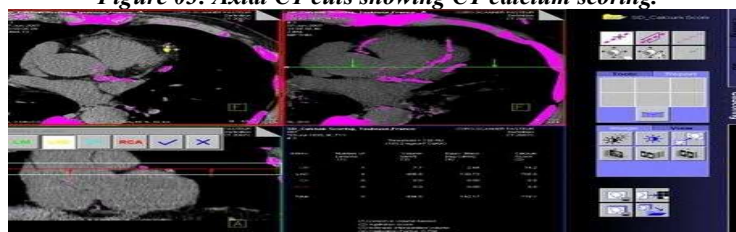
CT Workstation: Axial CT cuts showing CT calcium scoring.
